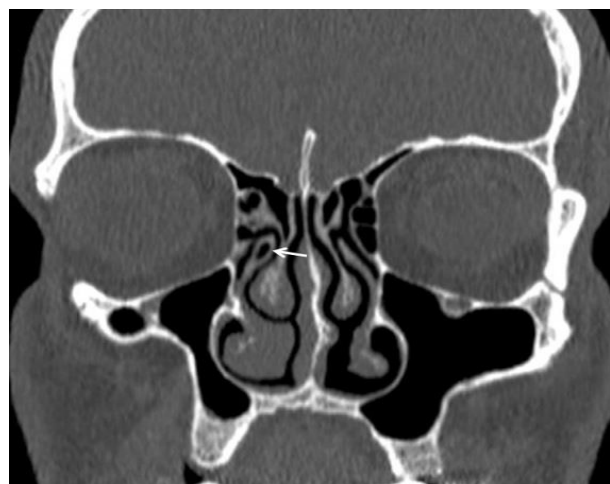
35-year-old man with right uncinata bulla. The arrow marks the uncinata bulla on paranasal CT: coronal view.
